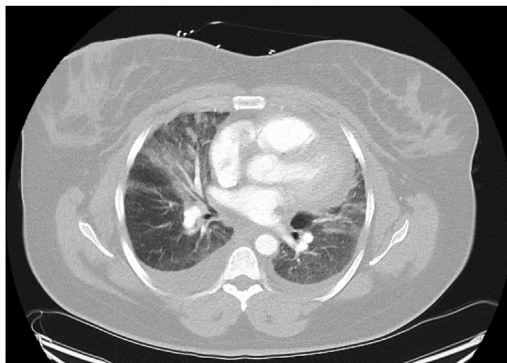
CT chest with contrast showing bilateral infiltrates and pleural effusions.
